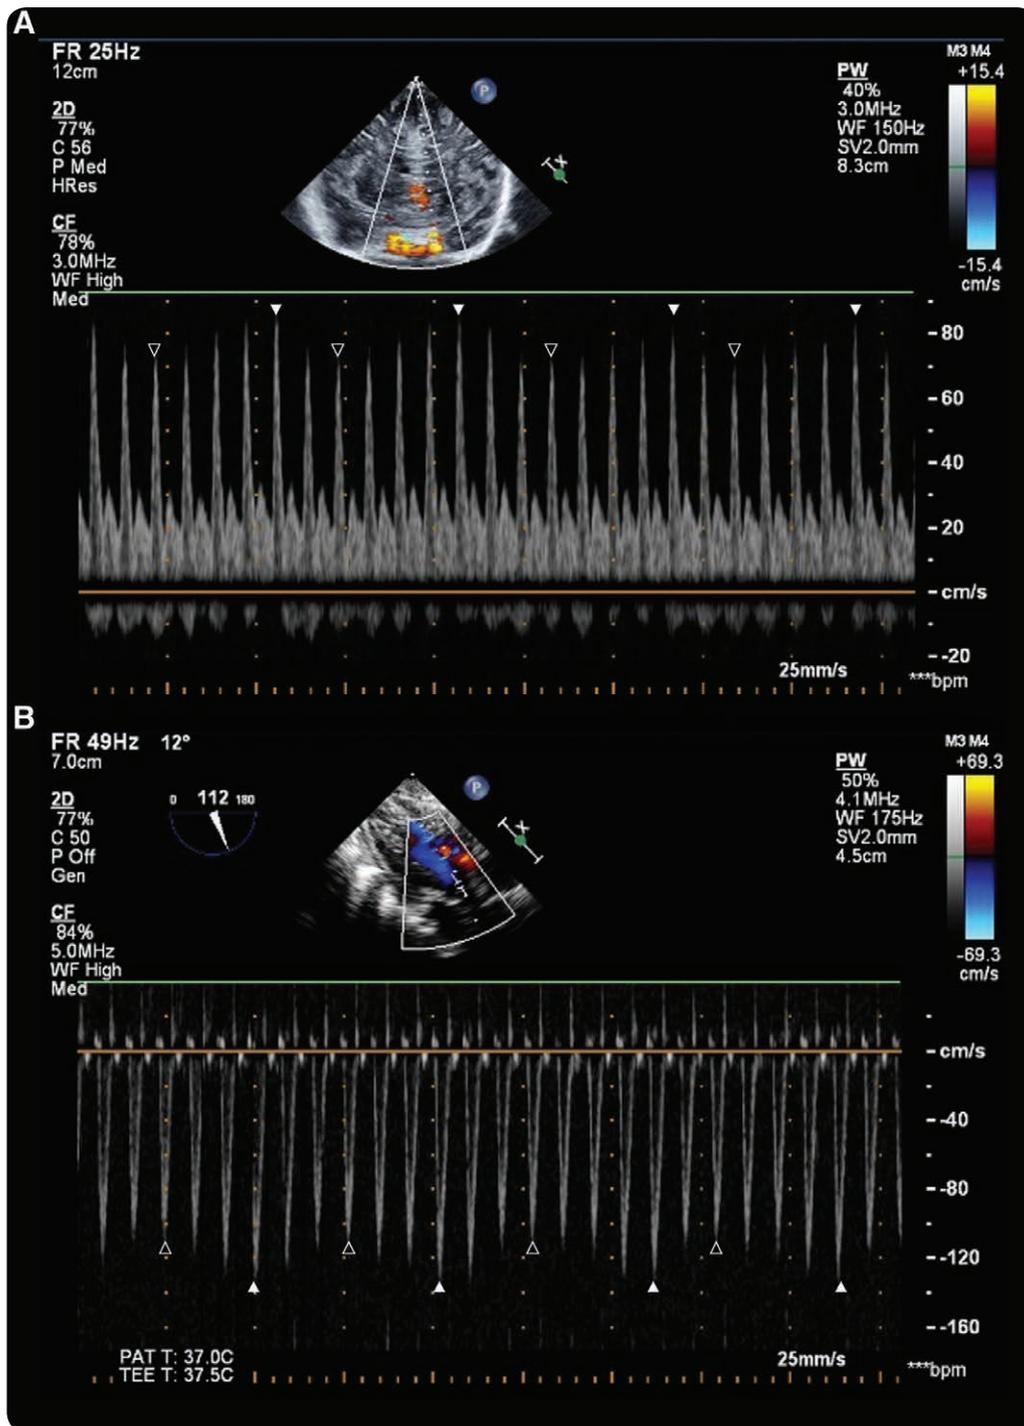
(A) Coronal plane image of the brain and the blood flow velocity at the internal carotid artery. (B) Deep transgastric long-axis view using pulsed wave Doppler, and the aortic blood flow waveform at the level of the aortic annulus. bpm, beats per minute; C, compression; CF, color flow; FR, frame rate; Gen, general; HRes, high resolution; Med, median; PAT T, patient temperature; P, persistence; PW, pulsed wave; SV, sample volume; TEE T, transesophageal echocardiography probe temperature; WF, wall filter; 2D, two-dimensional echo.
